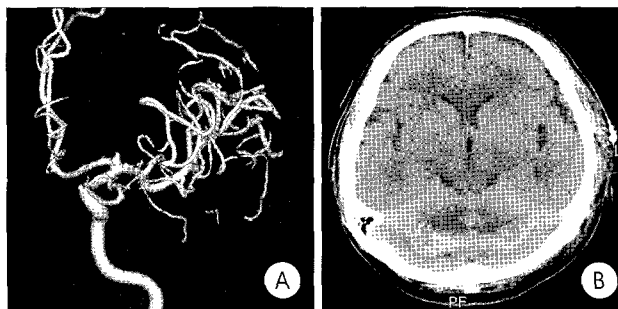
A : Three-dimensional digital subtraction cerebral angiography demonstrating a 3mm-sized saccular aneurysm at the left internal carotid artery, and it is a bifurcation aneurysm. B : Nonenhanced computed tomography scan at postoperative third day showing the bilateral cerebellar hemispheric and vermian hemorrhage.
